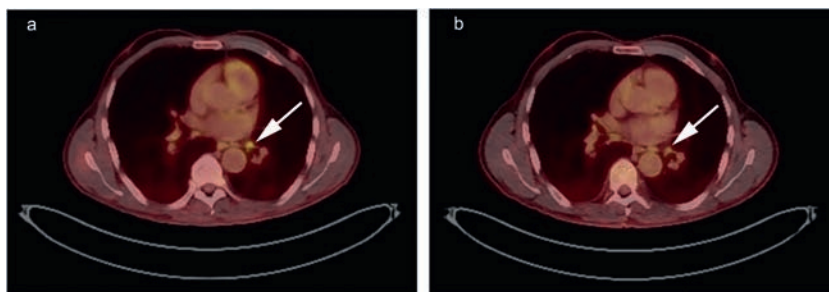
(a) FDG PET-CT scan with positive FDG uptake at baseline before initiation of cemiplimab. Note the FDG uptake in lymph nodes in the left lung hili (white arrow). (b) FDG PET-CT scan with reduced FDG uptake in the lymph nodes (white arrow) following 3 months of cemiplimab therapy.
